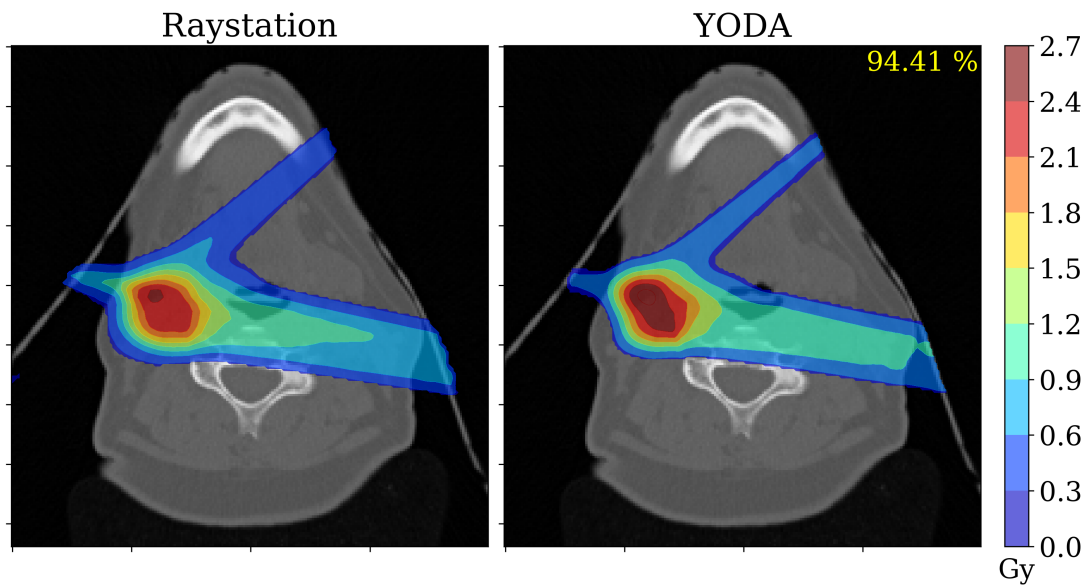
Dosimetric comparison between RayStation and YODA for the Patient 1. The figure displays RayStation (on the left) and YODA (on the right) two-dimensional dose cuts, overlaid on the corresponding CT slice. The figure displays in the top right corner of the YODA plot, the three-dimensional gamma index passing rate using 2 mm, 2% and 10% cut-off.
